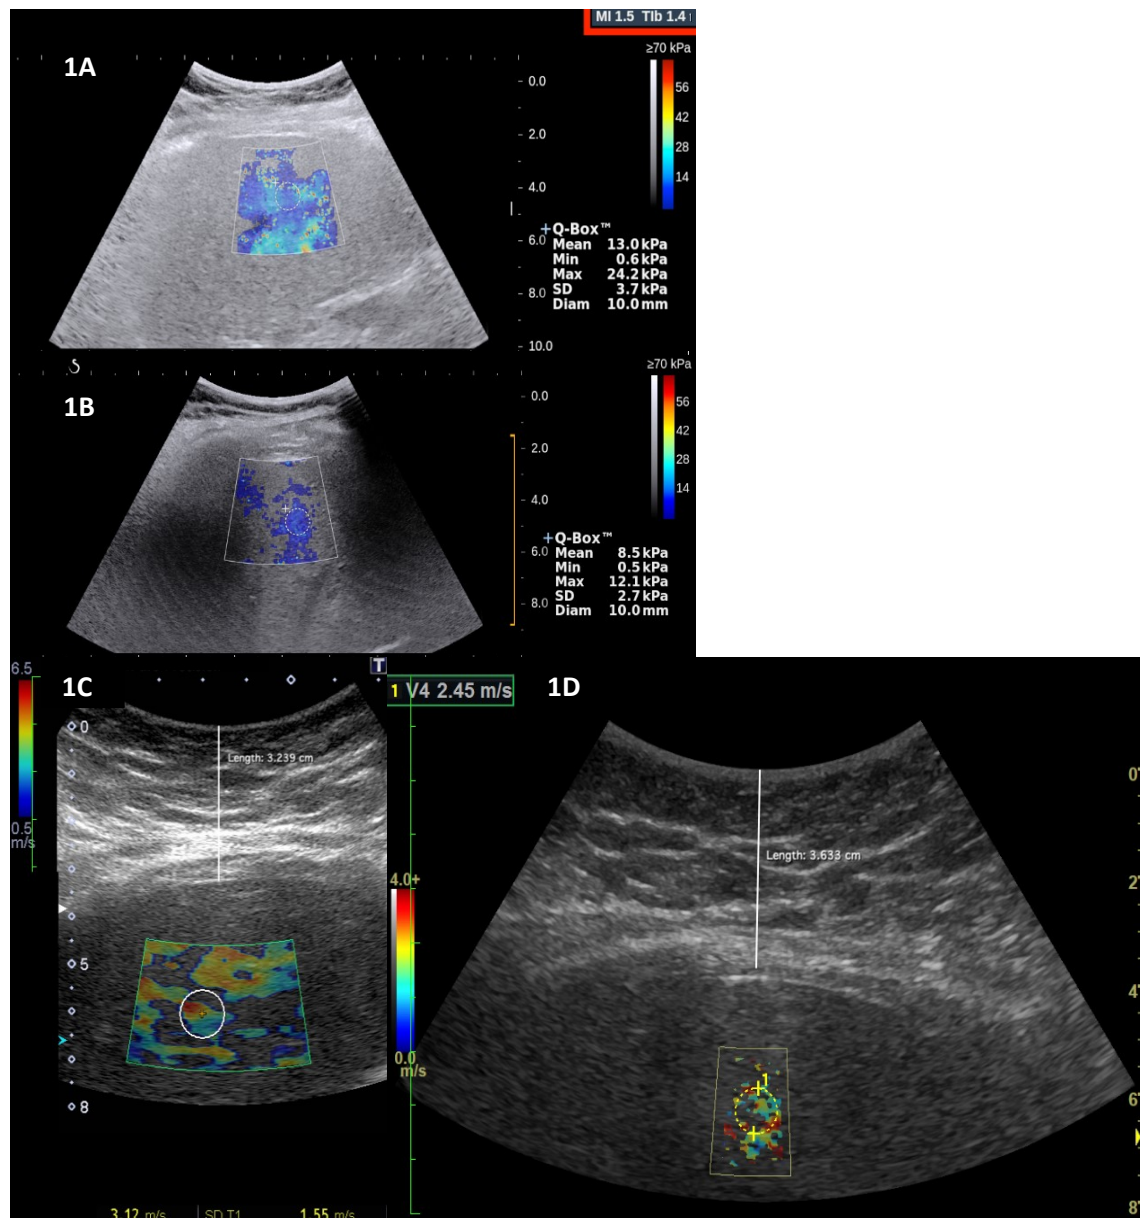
Standardized MI and TI display (red area) Ultrasound systems meeting the U.S. FDA 510(k) guidance for 'Track 3' systems will display TI and MI values on the ultrasound image. Figure1B. Unreliable SWE measurement with high SCD value. Figure1C, 1D: Poor region of interest (ROI) filling due to poor shear wave propagation. High skin to liver capsule distance may be an important factor for poor ROI filling.
